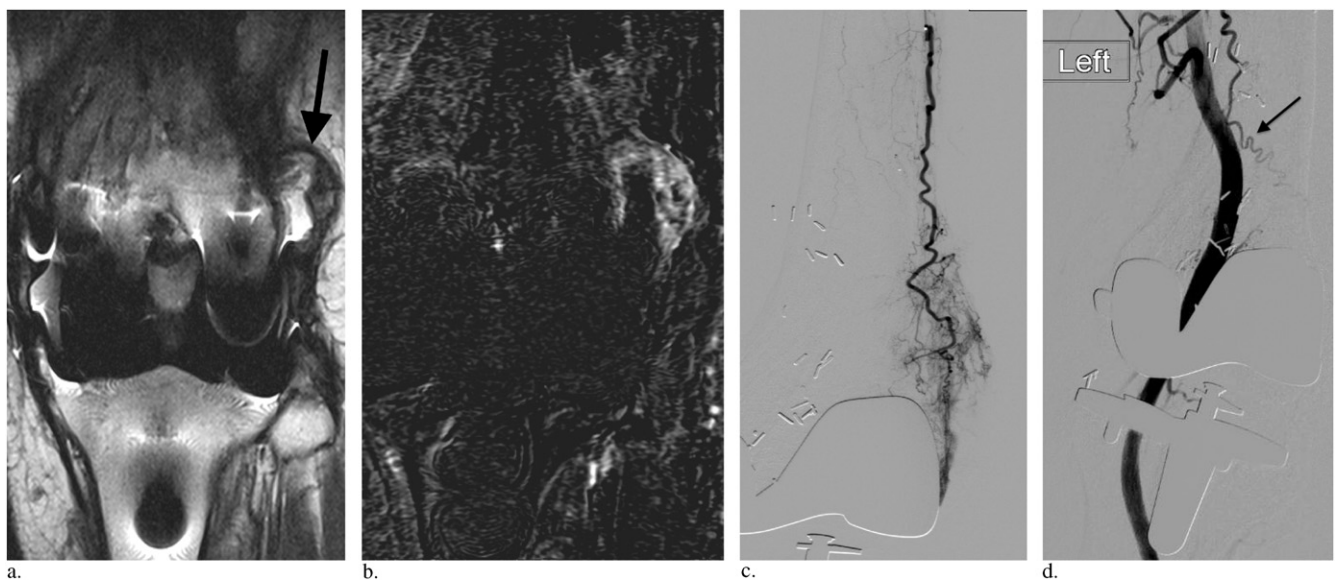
(a) Coronal T2 MR image demonstrates lateral superior synovial thickening (arrow). (b) Subtracted MR image after intravenous gadolinium injection shows increased synovial enhancement in the area of thickening. (c) Selective angiography of superior lateral geniculate artery shows hypertrophy and hypervascularity in the corresponding area of abnormal synovium. In this patient, the superior lateral geniculate artery originated from the profunda femoris artery, which highlights the importance of angiography of the superficial and profunda femoris arteries. (d) Angiography after embolization shows near-stasis in the superior lateral geniculate artery (arrow) with absence of hypervascular synovium.
